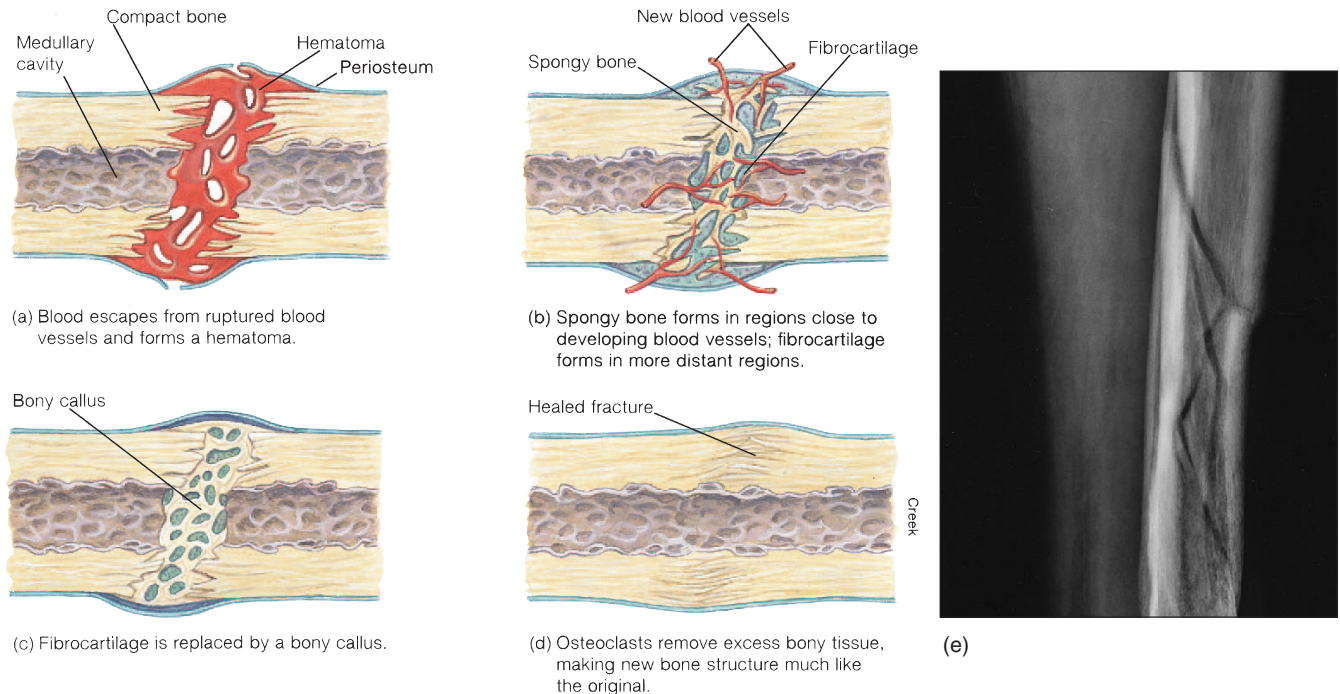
Stages (a–d) of the repair of a fracture. (e) A radiograph of a healing fracture.
